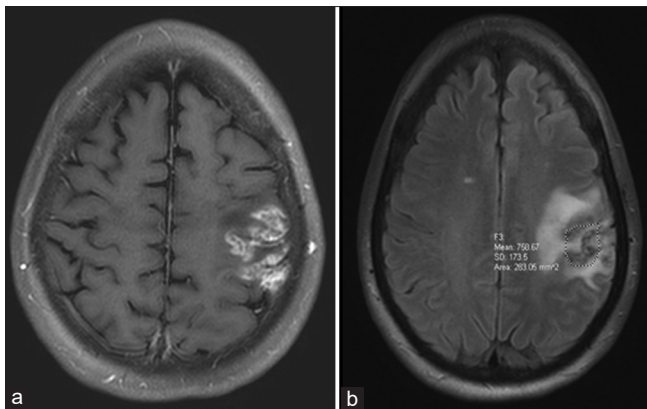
Neuroradiologic images on preoperatively. Representative axial T1-weighted postgadolinium contrast image (a) and axial T2-weighted FLAIR image (b).
